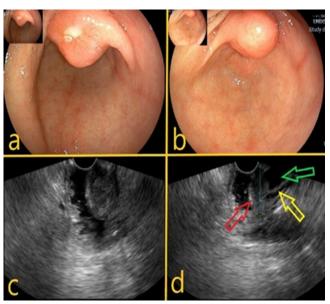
Endoscopic and endoscopic ultrasound images of major duodenal papilla. a,b) bulging and ulceration of the major duodenal papilla; c) echoendoscopic image of ampullary tumor restricted to the major duodenal papilla; d) echoendoscopic image of ampullary tumor (red arrow) and dilatation of the main bile duct (green arrow) and Wirsung duct (yellow arrow).
